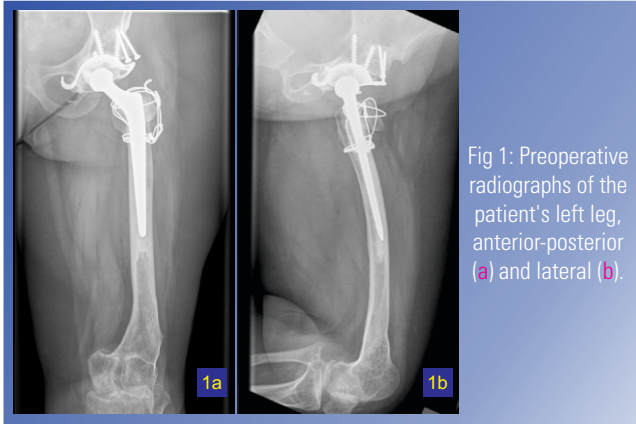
Preoperative radiographs of the patient's left leg, anterior-posterior (a) and lateral (b).
